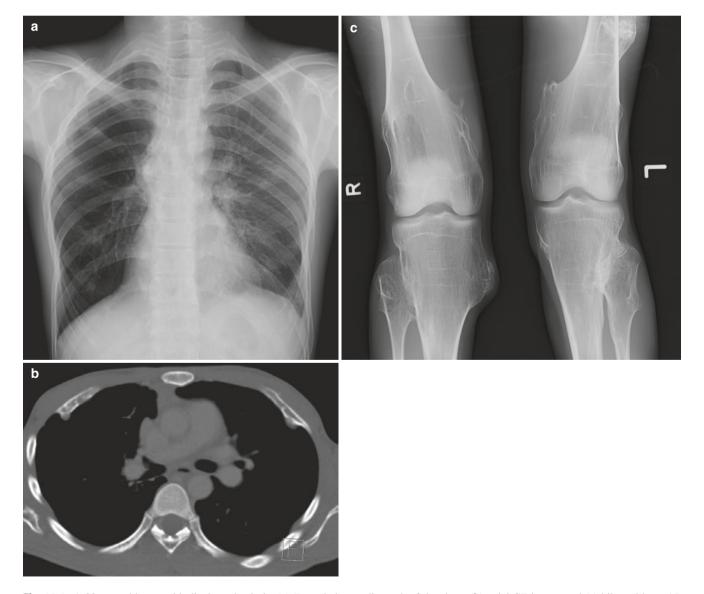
A 28-year-old man with diaphyseal aclasis. (a) Frontal chest radiograph of the chest, (b) axial CT image, and (c) bilateral knee AP radiographs show multiple bony protuberances representing multiple exostoses
